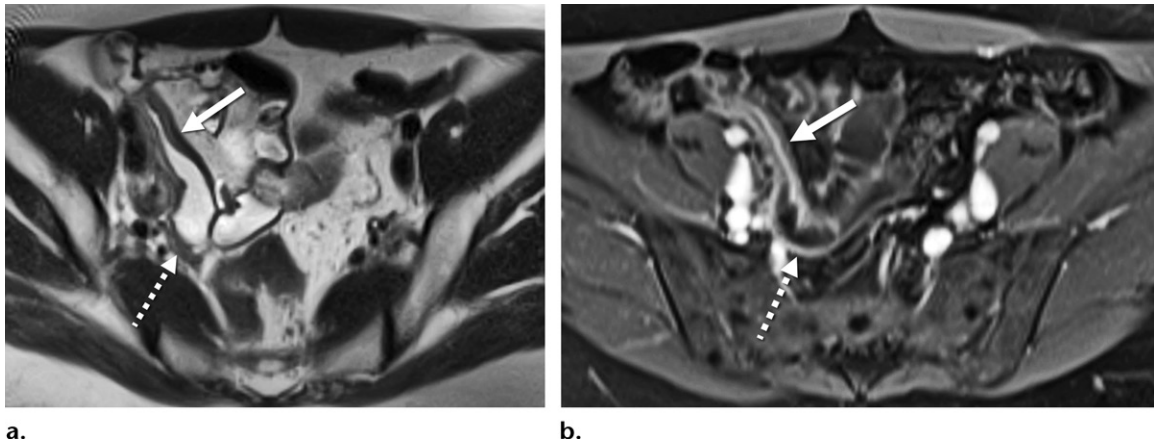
Active inflammatory small bowel Crohn disease with luminal narrowing. Axial T2-weighted (a) and contrast-enhanced fat-suppressed T1-weighted (b) MR enterographic images with biphasic oral contrast material in a patient with Crohn disease show mild wall thickening, mural edema, and stratified mural hyperenhancement (solid arrow) in the terminal ileum, with luminal narrowing but without dilation of the upstream small bowel (which measures <3 cm) (dashed arrow), consistent with active inflammatory small bowel Crohn disease with luminal narrowing.
